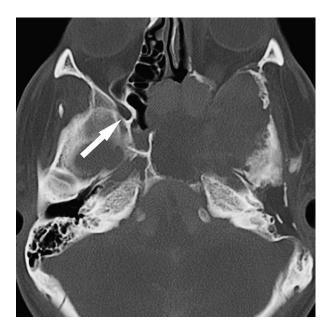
Axial CT of the skull base. Note the destruction of nearly the entire left skull base, affecting not only the pterygopalatine fossa (white arrow indicates the normal right), but the apex of the petrous bone, including the carotid canal.
